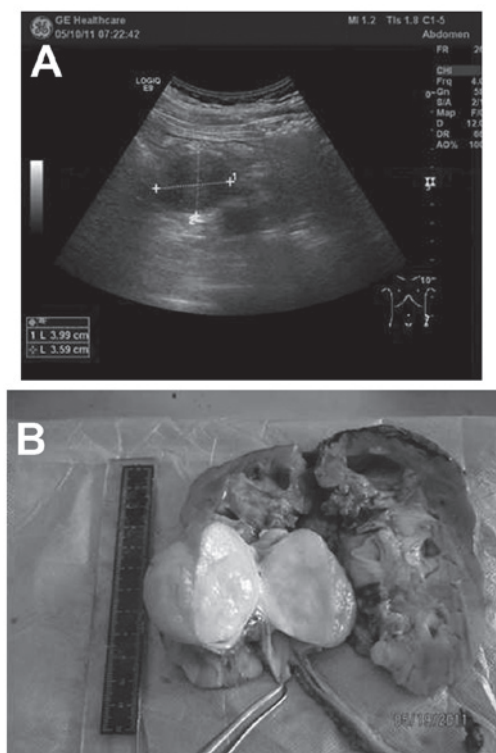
(A) Ultrasonic examination revealing left hydronephrosis and a space-occupying lesion in the left ureter. (B) Tumor positioned under the ureter, the with a volume of ~5x4x3.6 cm. The boundaries of the mass were clear and the section was faintly yellow.
